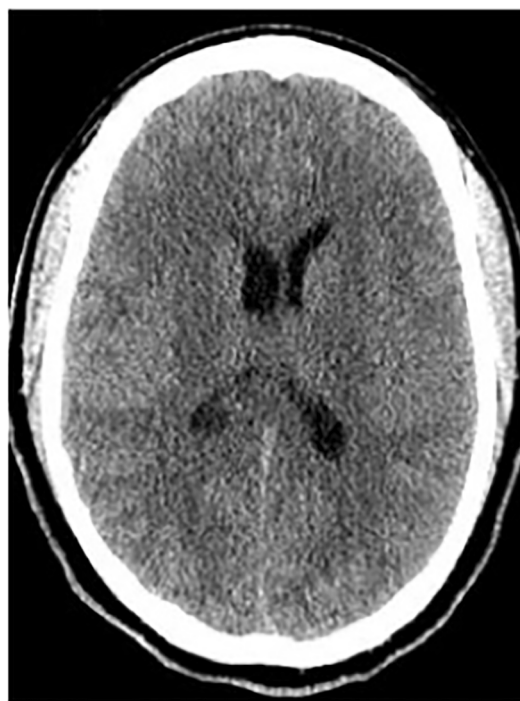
Axial CT head at presentation which demonstrates mild hydrocephalus and poor visualization of sulci.
